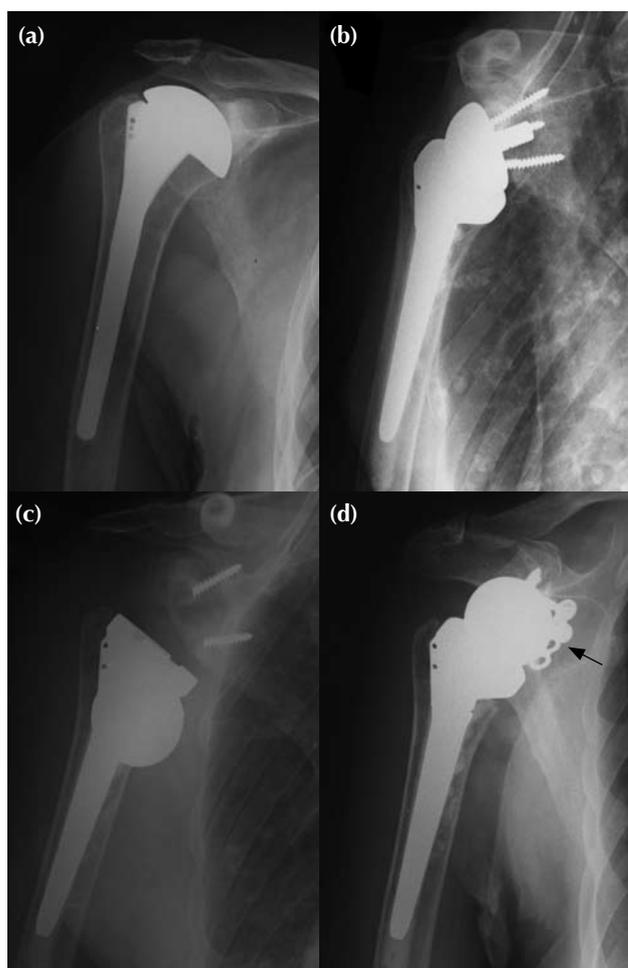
Radiographs showing (a) an unstable unconstrained shoulder prosthesis associated with pain and pseudoparalysis in a rheumatoid patient, (b) a Delta 3 prosthesis after revision arthroplasty, (c) gross loosening of the glenoid component with breakage of 2 screws 6 months later, and (d) after replacement of the glenoid component using a special metaglene with a plate for additional screw fixation (arrow). The bone defect in the scapular neck is filled with cancellous bone grafts.
